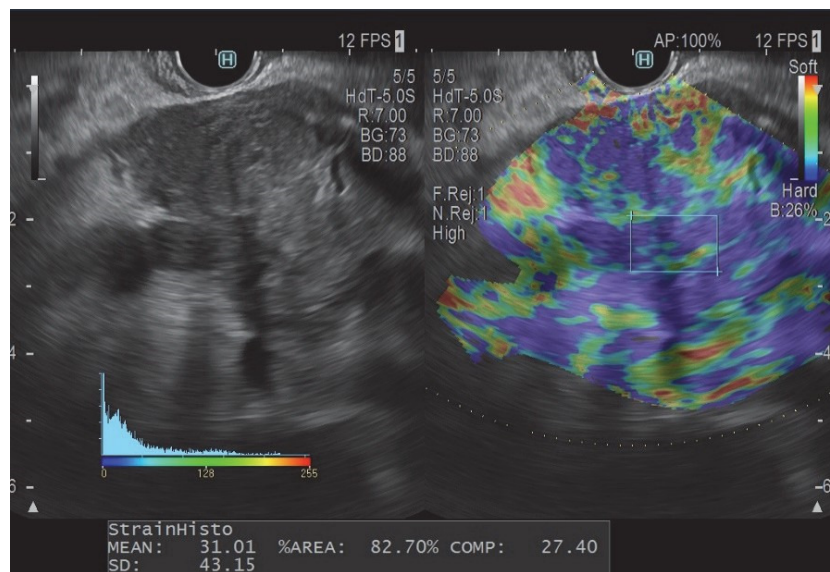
Strain-Type Endoscopic Ultrasound Elastography
